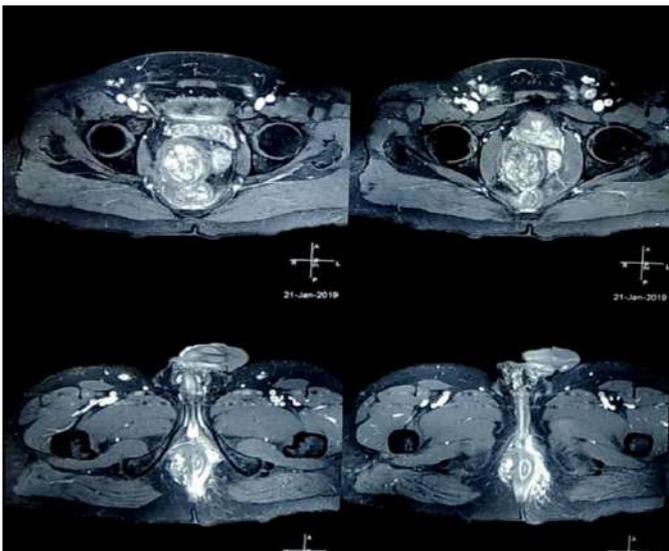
Anteroposterior extension of mass shown in MRI
